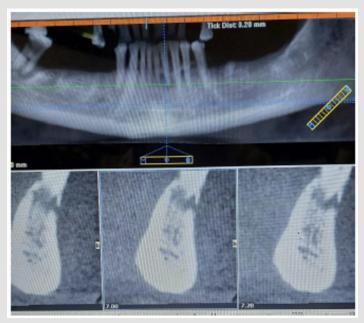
CBCT cross sectional showing sequestration of bone under lower left central and lateral.
